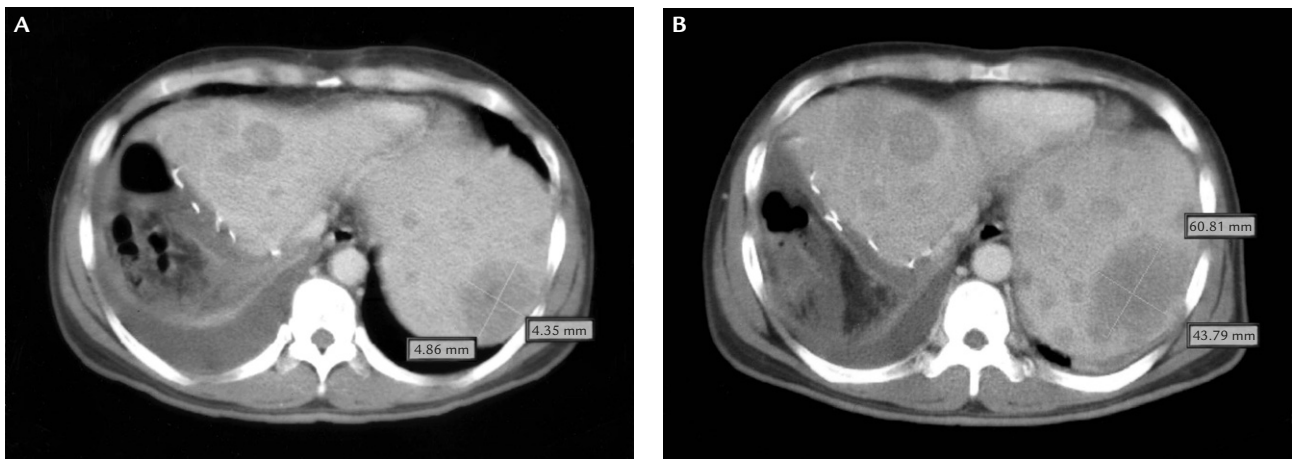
Computed tomography shows progressive disease with increase in size of liver metastases within a month despite debulking surgery and chemotherapy.
